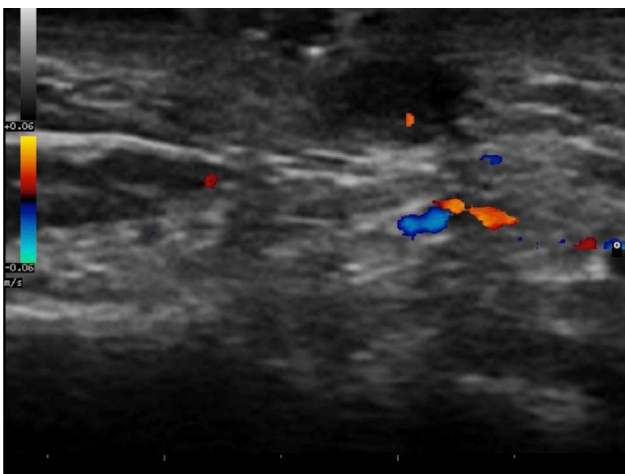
Doppler study showing vascularization of the area around the tract, suggesting inflammation.
